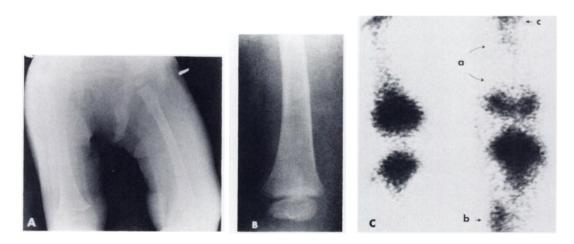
(A) Initial radiograph shows soft-tissue swelling in left thigh. (B) Closeup view of distal left femur shows no bone abnormality. (C) Anterior ^{99m}Tc-pyrophosphate scan of both knees shows decreased activity in distal metaphysis of left femur (a). Note injection artifact in left calf medially (b) and edge-packing artifact in femur (c). Subperiosteal pus surrounding distal left femoral metaphysis was drained immediately after this study. Arteries to distal metaphysis were found to be occluded.
